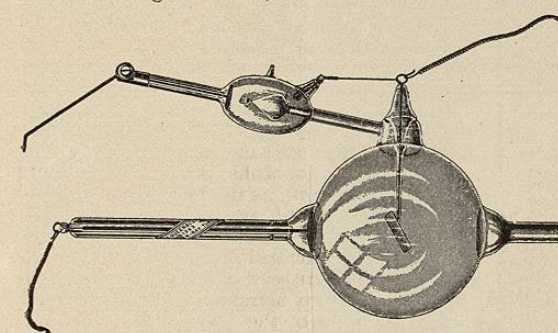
Queen Self-Regulating X-Ray Tube.
